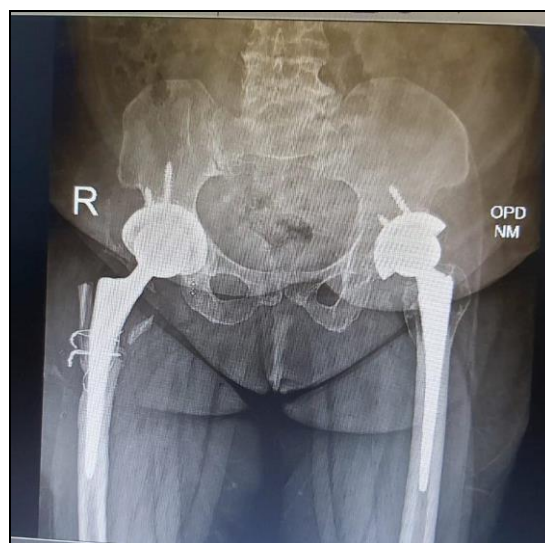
Digital Xray film pre-operative
